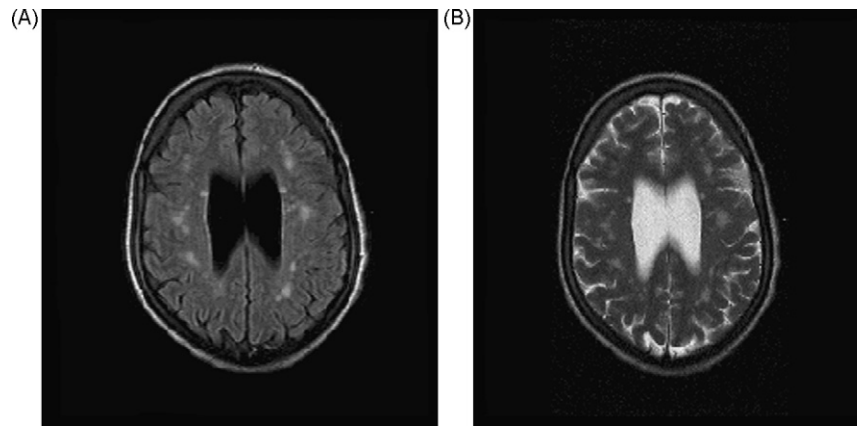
White matter changes on MRI. (A) T1-weighted. (B) T2-weighted.
